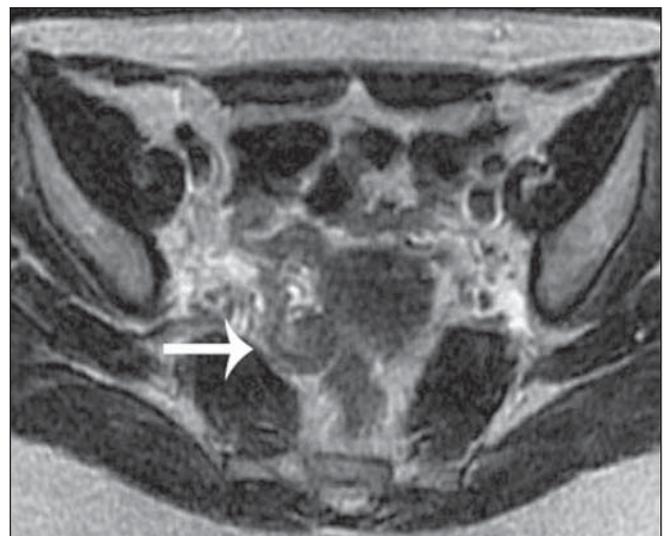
Endometrioma. Axial MRI T2-weighted sequence acquired with a 0.2 T scanner, representing signal loss as compared with T1-weighted water-image.
